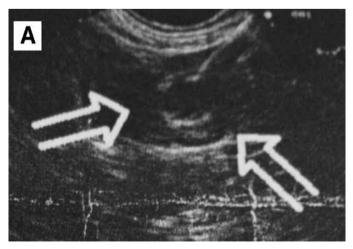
The endoscopic ultrasonography image of the patient in case 2 displays a well-demarcated tumor in the tail of pancreas
